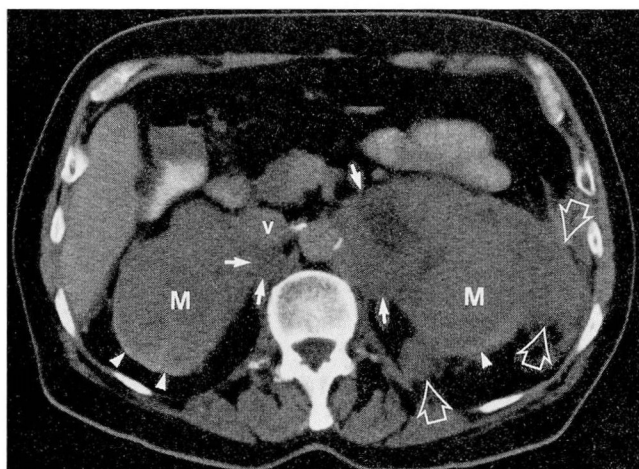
Contrast-enhanced CT scan through the upper kidneys demonstrates bilateral bulky nonenhancing masses replacing the renal parenchyma (M) and extending into the periaortic region bilaterally (solid arrows) with anterior displacement of the inferior vena cava (V). Also note involvement of the left perinephric space (open arrows). A very small rim of renal cortex can be seen posteriorly (arrow heads).
